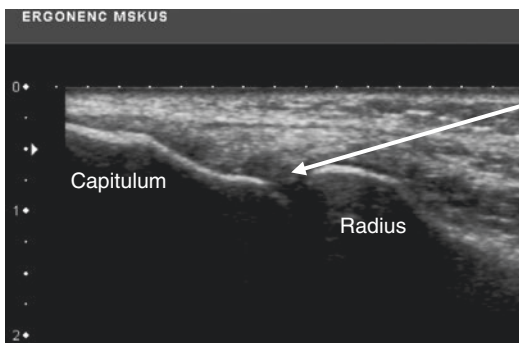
Long-axis sonogram of the radiocapitellar joint. In-plane approach
